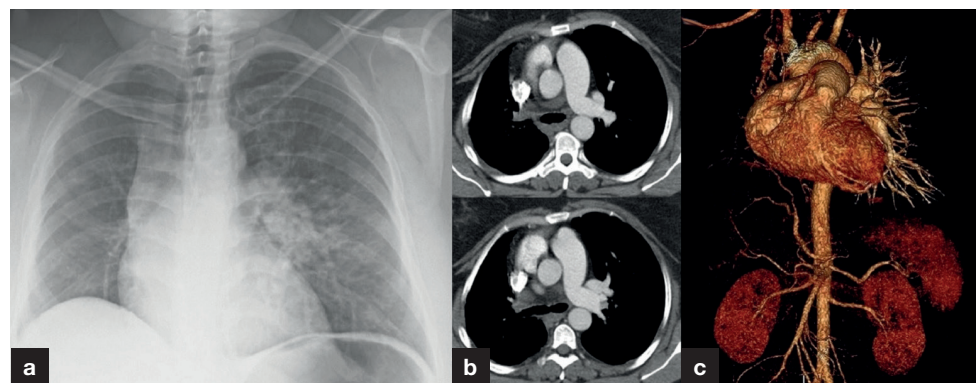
a. Chest X-ray demonstrating engorged left pulmonary trunk and decreased right lung markings; (b) computed tomography and (c) reconstructed angiography showing interruption of the right pulmonary artery.
